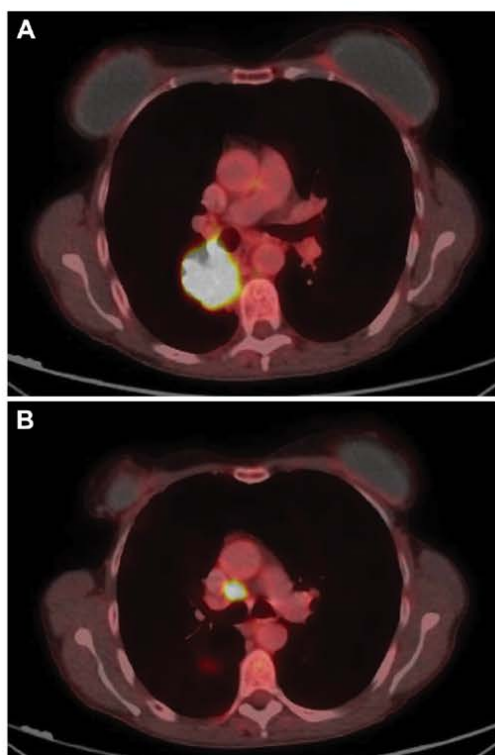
A 59-year-old woman with a pulmonary mass in the right lower lobe presented with a PET/CT showing high FDG uptake (A) in the pulmonary mass and (B) in a right lower paratracheal (4R) node with no other mediastinal uptake. The systematic EBUS-TBNA staging started sampling the N3 nodes: a left hilar (11L) node and two left lower paratracheal (4L) nodes. The ROSE did not show malignancy in any of them. The staging procedure then proceeded to the subcarinal nodal station, where a node was consistent with malignancy. Once the needle was changed to avoid contamination, the 4R node was sampled and the ROSE confirmed multiple nodal disease (N2b). In a targeted EBUS-TBNA staging scenario, only one node (4R) would have been sampled. Although the length of the procedure would have been shorter with targeted EBUS-TBNA sampling of only 1 node, this would have notably reduced the clinical information compared with that obtained with systematic EBUS-TBNA, where 5 nodes were sampled.
